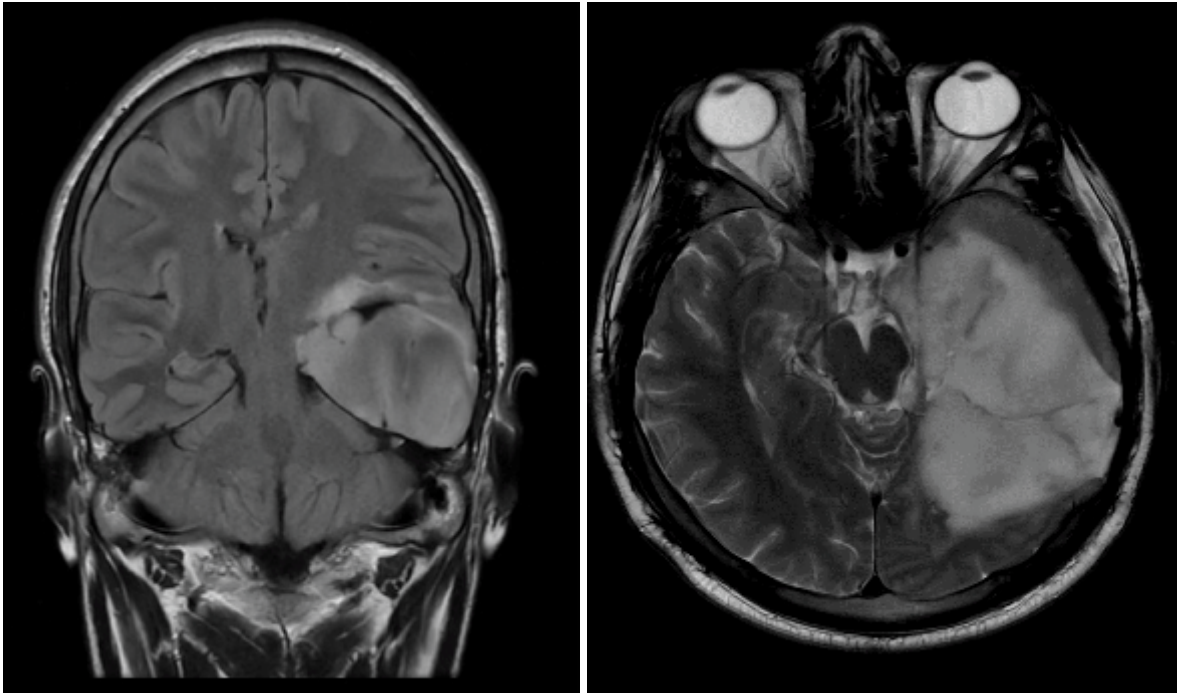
Radiology Images showing T2/FLAIR Mismatch, Coronal FLAIR and axial T2 weighted image.
